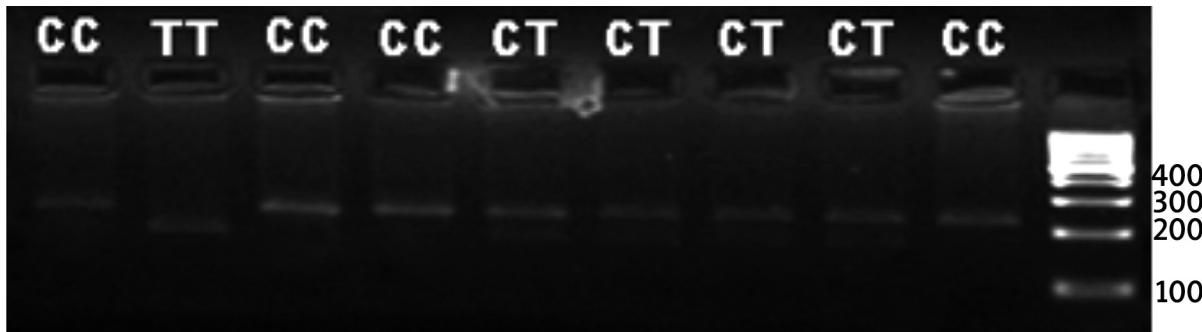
Results of the RFLP analysis. The length of the PCR product containing the polymorphism 665C/T was 227 bp (CC); after digestion with FastDigest® Hinfl enzyme, fragments of 179 bp and 48 bp (genotype TT), and fragments of 227 bp, 179 bp and 48 bp (CT) were produced
